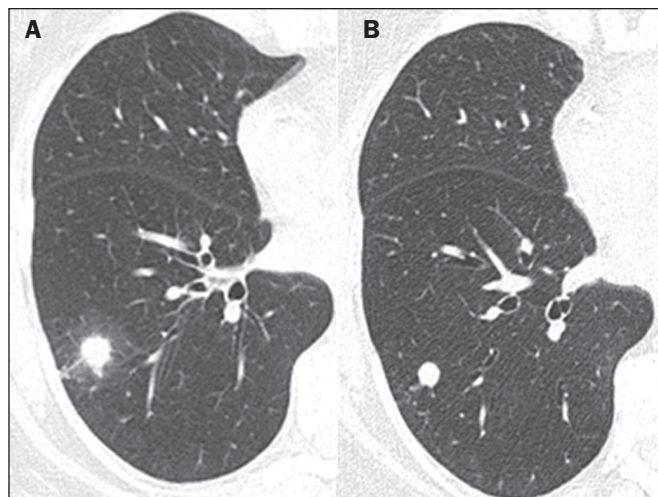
A 57-year-old man. A: CT showing a nodule with a ground-glass halo in the right lower lobe. B: Control CT examination performed nine months later, showing a nodule with smooth, regular contours, without a ground-glass halo.
